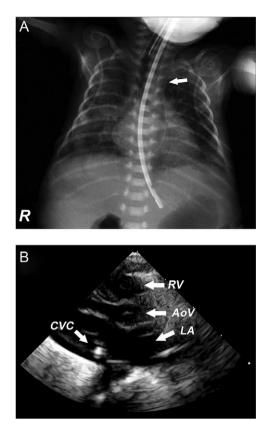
(A) chest x-ray showing central venous catheter that runs through the left mediastinum indicating a persistent left superior vena cava (arrow). (B) Transthoracic echocardiography in a parasternal longitudinal axis showing the central venous catheter (CVC) within an enlarge coronary sinus, additionally the left atrium (LA), aortic valve (AoV) and right ventricle (RV) are shown
